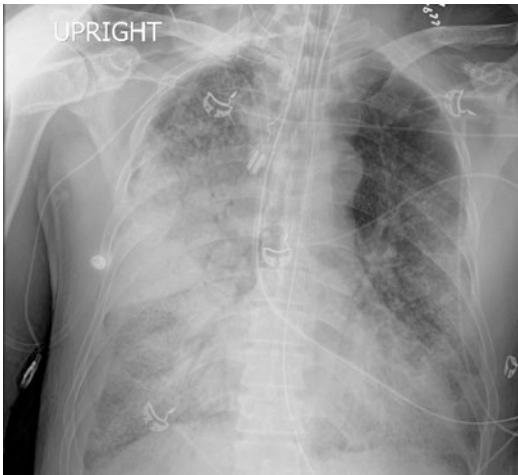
Chest X-ray of a patient showing bilateral lung opacities consistent with ARDS
